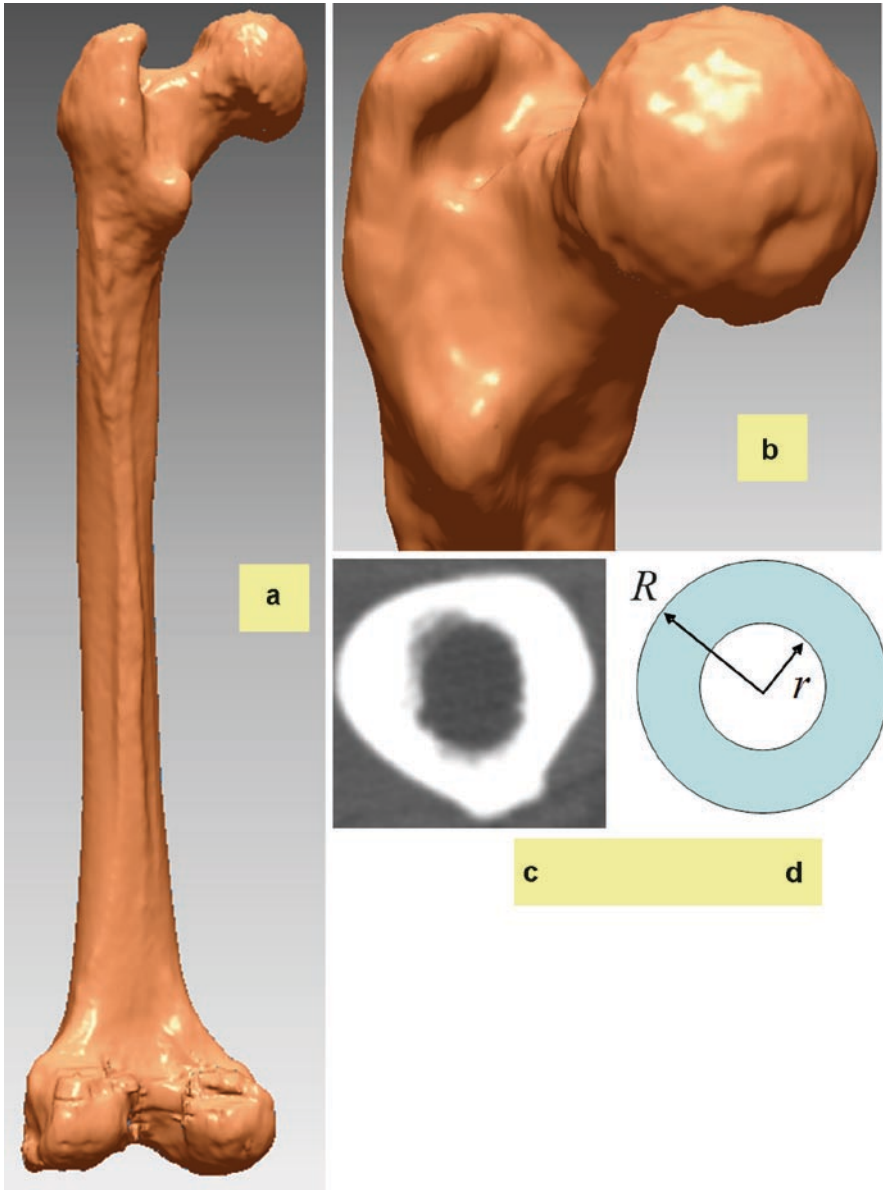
A human femur. (a) Femur model built from CT scan images; (b) proximal head; (c) cross-section of diaphysis; (d) hollow circular section. Courtesy of Dr. Beat Schmutz, Queensland University of Technology, Australia.
